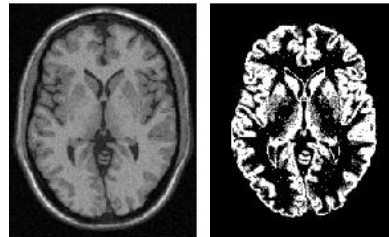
A T1-weighted MR image and gray matter PVCs estimated from it.
